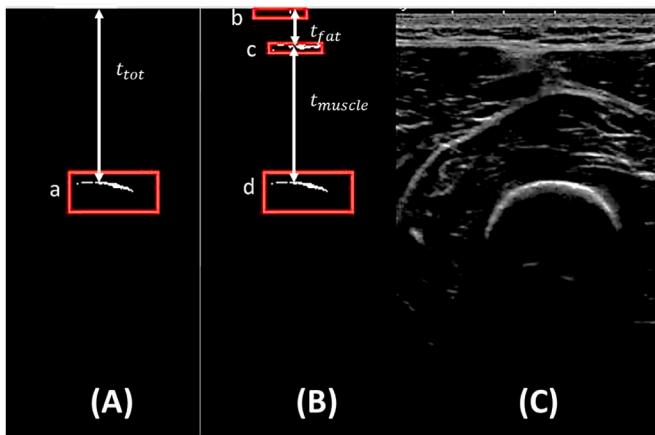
(A) example of the tracked interface in the research from (Fougeron et al., 2020) a: Tracked bone contour. (B) example of the tracked interfaces in this research b/Skin, c/muscle/adipose tissue interface d/femur. (C), associated B-mode ultrasound image.
